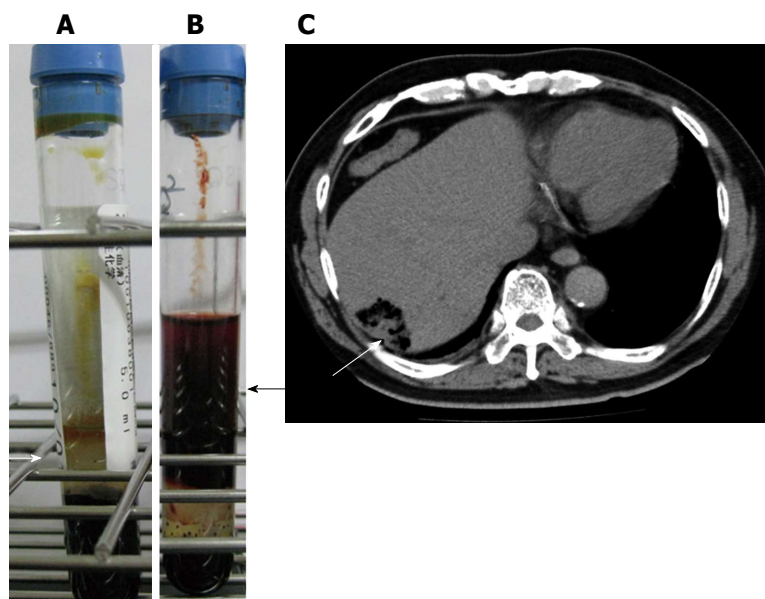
The serum color before and after massive hemolysis and computed tomography imaging results. A: Patient serum color on admission showed no sign of hemolysis (white arrow); B: The dark red color of serum taken during CPR indicated massive hemolysis (black arrow); C: Computed tomography of the abdomen revealed a 4 cm × 2 cm abscess with gas formation in the right lobe (white arrow).
